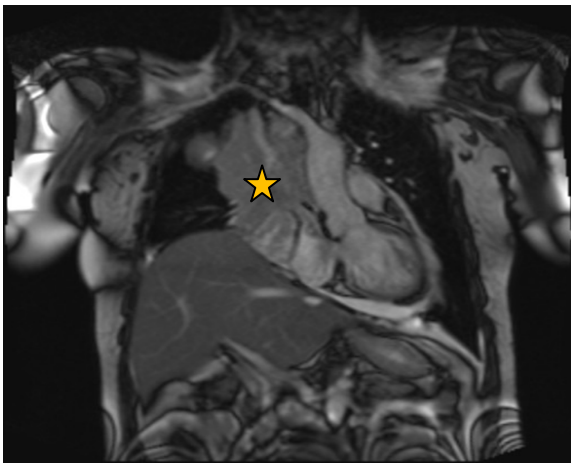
Cardiac magnetic resonance imaging demonstrated anterior mediastinal mass (asterisk) invading the right atrium.
